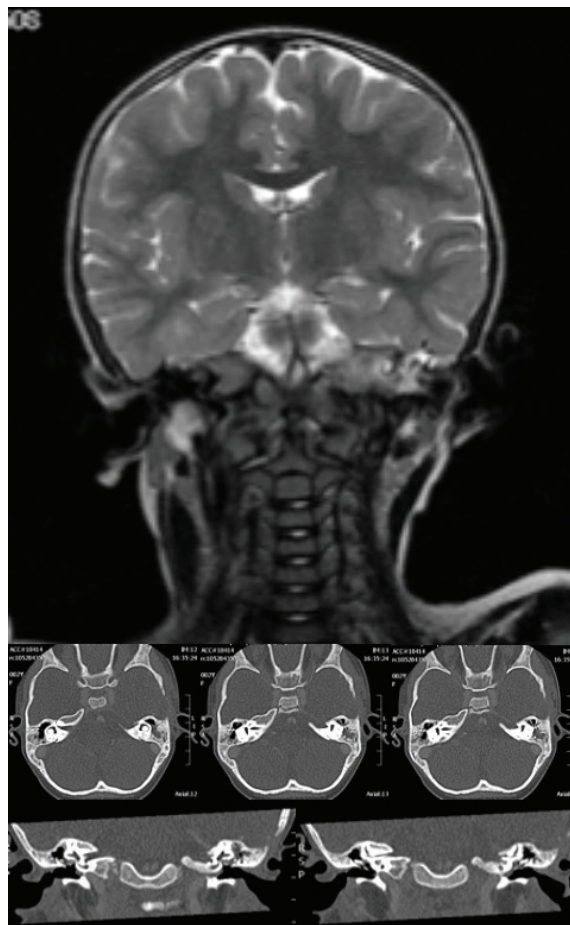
Six weeks CT scan after chemotherapy showing osteolytic mass resolution, osteoneogenesis and postoperative changes.
